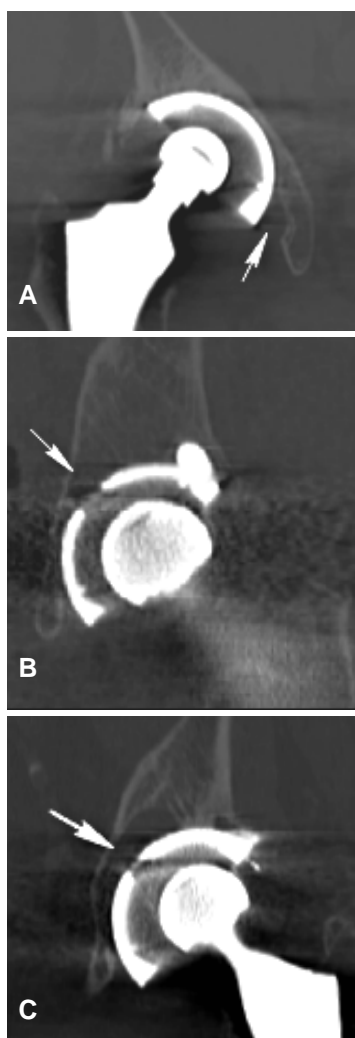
Sagittal and coronal CT images showing (A) rim-related, (B) hole-related and (C) combined osteolytic lesions (indicated by arrows) adjacent to PCA acetabular components.
